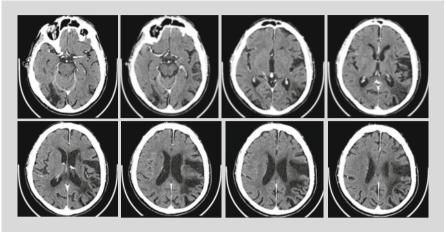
Brain transverse CT sections Showing multifocal strokes (in the superficial posterior cerebral artery territory on the *right* and in the superficial middle cerebral artery territory on the *left*)
